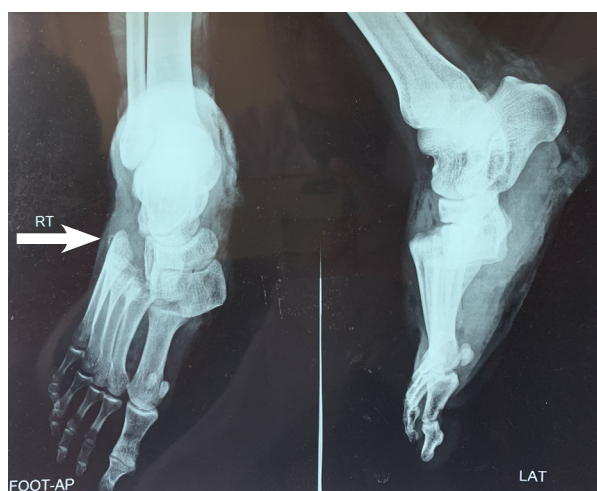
X-ray at injury showing Myerson Type A Lisfranc fracture dislocation
